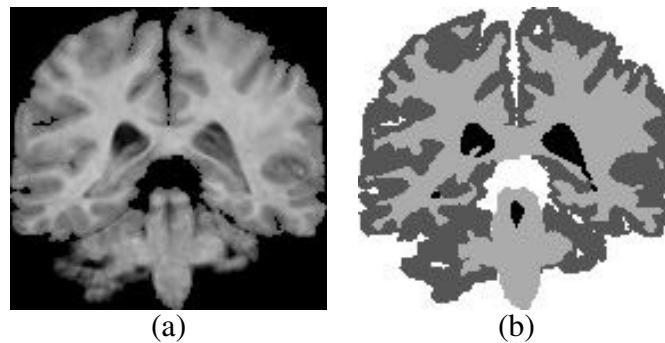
(a) Original T1-weighted coronal slice of a volume from IBSR 20 normal brain data set, and (b) its corresponding manual segmentation.
